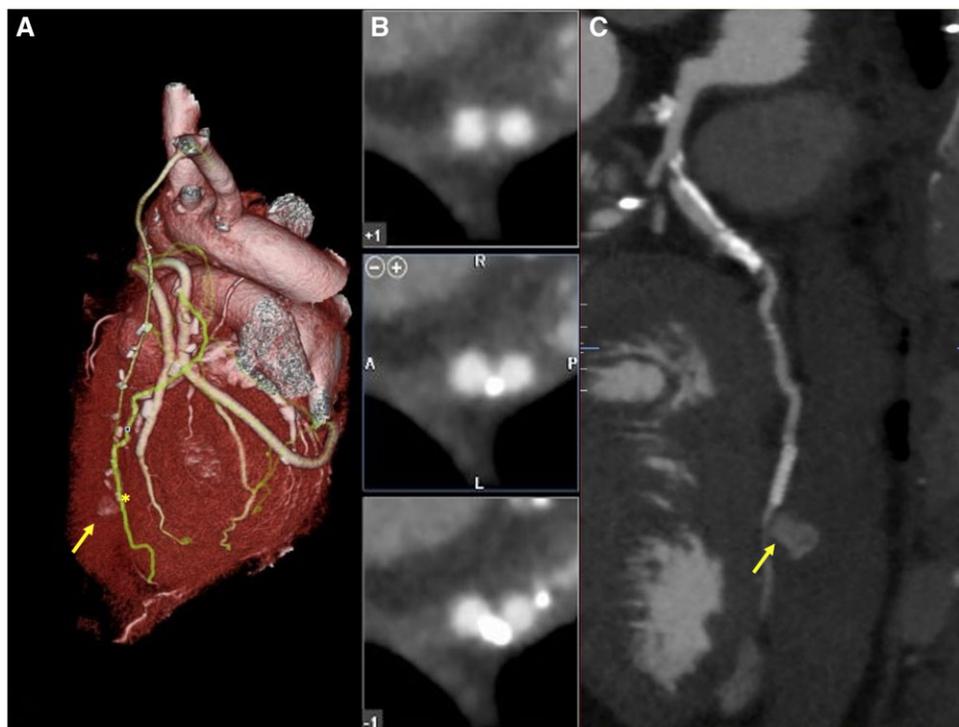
Coronary computed tomography with three-dimensional reconstruction. In Panel A, the yellow arrow marks the pseudoaneurysm. In Panel B, the central bi-dimensional cut-plane is at the level of the yellow asterisk, the other two panes of cut-plane are 1 cm above and 1 cm below the asterisks. In Panel C, it is showed the bidimensional reconstruction of the bypass graft with pseudoaneurysm of the left anterior descending artery close to the distal part of arterial graft anastomosis (yellow arrow).
